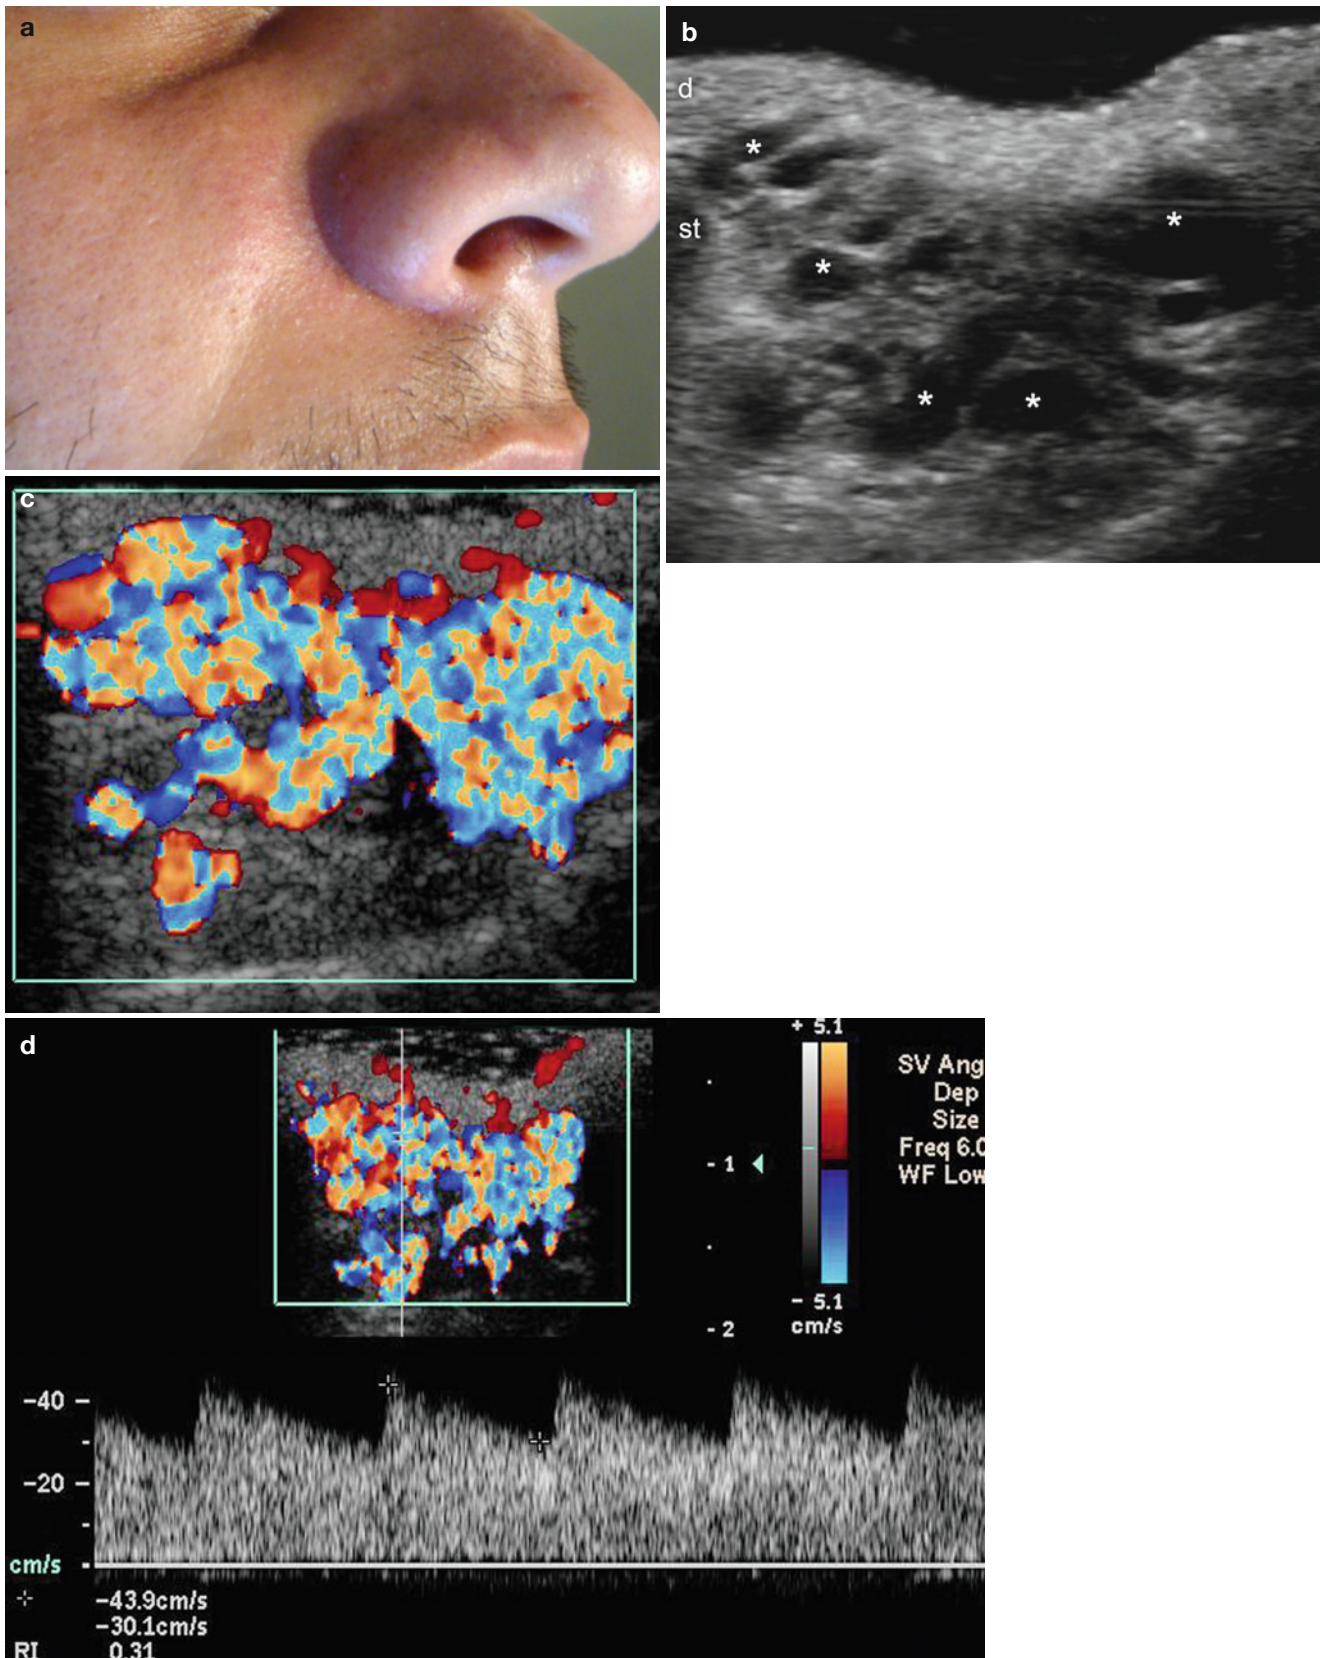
(a–d) Arterial vascular malformation. (a) Clinical image shows a erythematous lump in the right nasofold line. (b) Ultrasound image (gray scale, transverse view) demonstrates multiple anechoic tubules and pseudocystic areas (*) in the subcutaneous tissue. (c) Color
